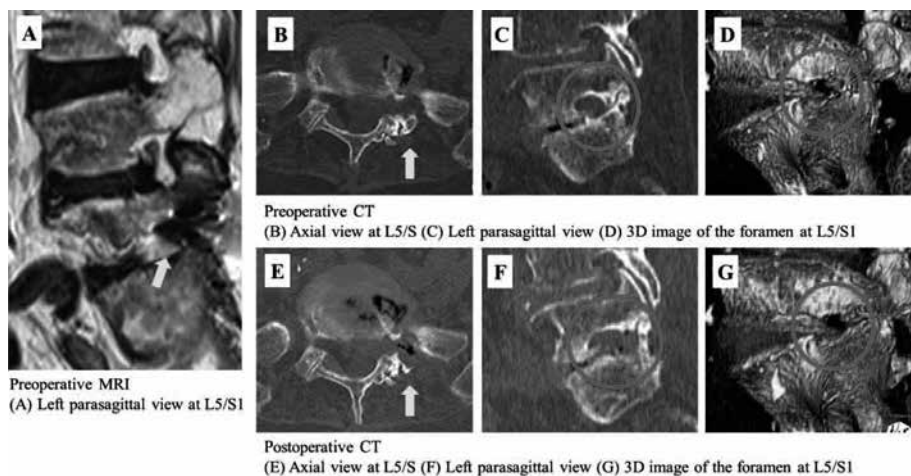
Case 3. (A) Left parasagittal MRI scan shows narrowing of the foramen at L5/S1. (B-D) Preoperative axial scan at L5/S1 and parasagittal and 3D CT scans show foraminal stenosis on the left side at L5/S1. (E-G) Postoperative axial scan at L5/S1 and parasagittal and 3D CT scans confirm partial resection of superior and inferior articular processes on the left, resulting in enlargement of the L5/S1 foramen after surgery. 3D, 3-dimensional; MRI, magnetic resonance imaging; CT, computed tomography
